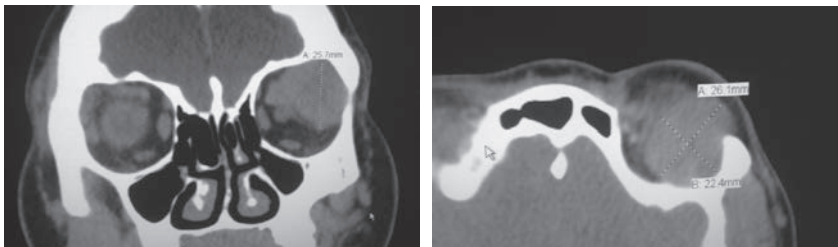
CT coronal and axial images displaying a well-circumscribed left lacrimal mass producing a mass effect on the globe and scalloping of the frontal bone.
